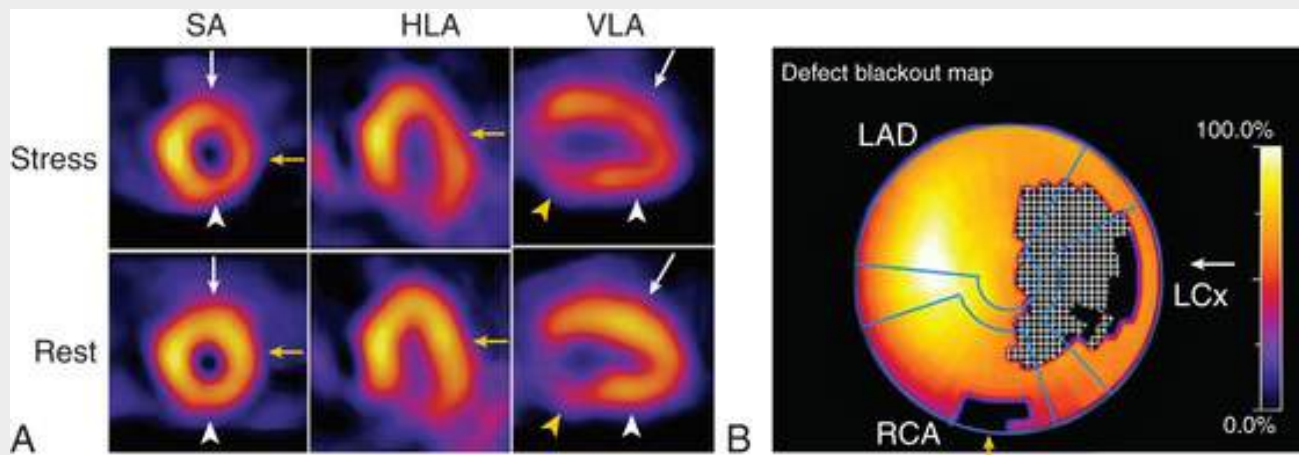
Examples of SPECT stress-rest perfusion imaging findings of extensive ischemia in all vascular territories and a small infarct. A, Reversible defects in the anterior wall and apex (*white arrows*), lateral wall (*yellow arrows*), and inferior wall (*white arrowheads*), consistent with inducible ischemia in all those territories. There is a small, fixed defect in the base of the inferior wall in the vertical long-axis (VLA) tomograms (*yellow arrowheads*), consistent with a small infarct. B, The polar map quantitation documents defects crossing into all vascular territories, with extensive reversibility (*white cross-hatched area, white arrow*), and a small irreversible area in the basal inferior wall (*blacked-out area, yellow arrow*). SA, Short-axis; HLA, horizontal long-axis view; LAD, left anterior descending artery; LCx, left circumflex artery; RCA, right coronary artery.
